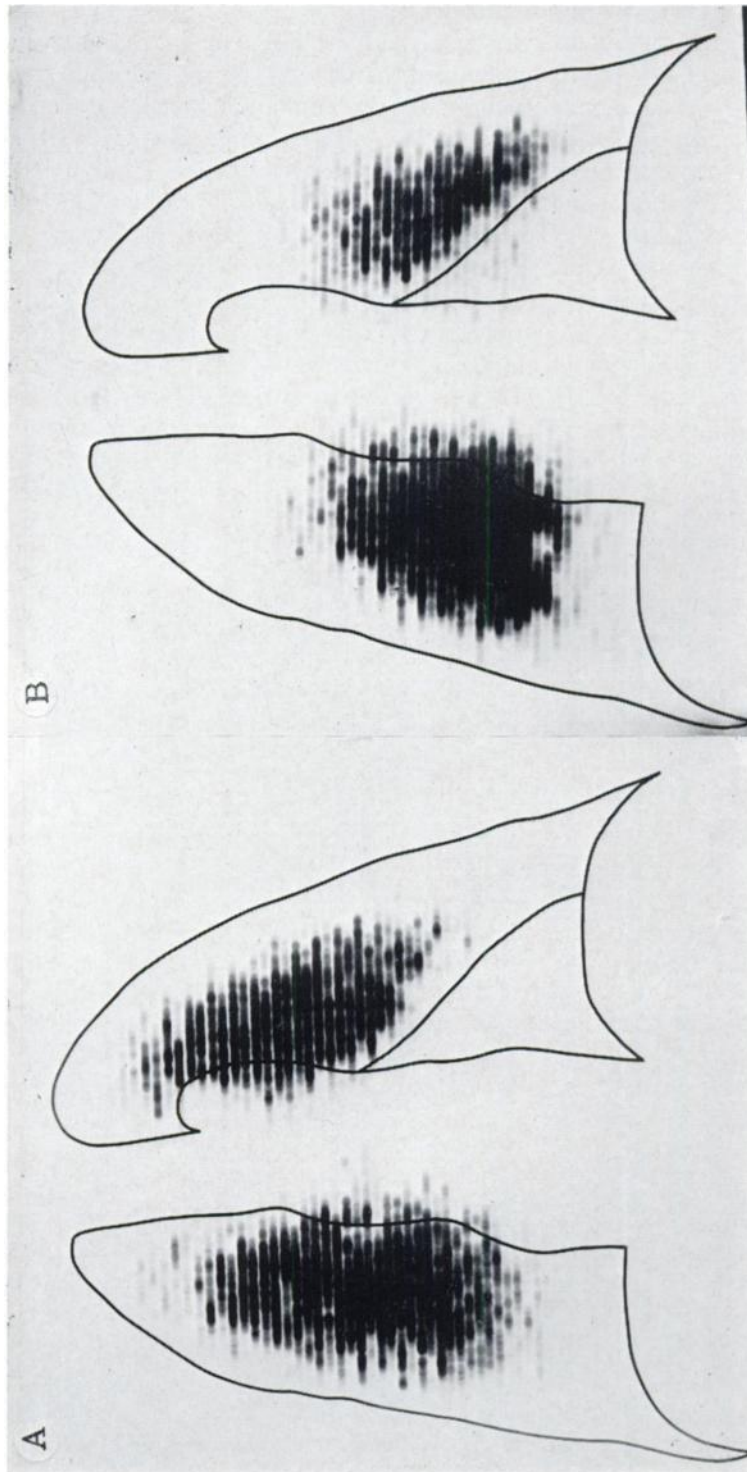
Anteroposterior scans of lungs made in normal subject following injection of ^{131}I -labelled macroaggregates of albumin while subject was in head-down position (-1G) (a) and one week after injection while subject was standing (b). Over both views were superimposed tracings that outlined lungs and were derived from nonparallax x-rays. Note shift in activity with change in direction of gravitational vector.
